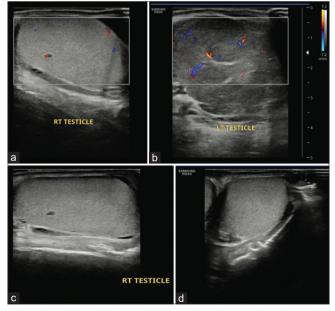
(a, c, and d) Ultrasonography examination confirmed a normal size and shape of the right testicle, homogeneous parenchyma, with no intra-parenchymal hypoechoic/hyperechoic lesions. The epididymis was not enlarged, homogeneous parenchyma and no intraparenchymal hypoechoic/hyperechoic lesions were seen. Testicular veins were not dilated. In contrast, (b) ultrasound Doppler showed a generalized enlargement and hypoechoic left testis with increased vascularity
